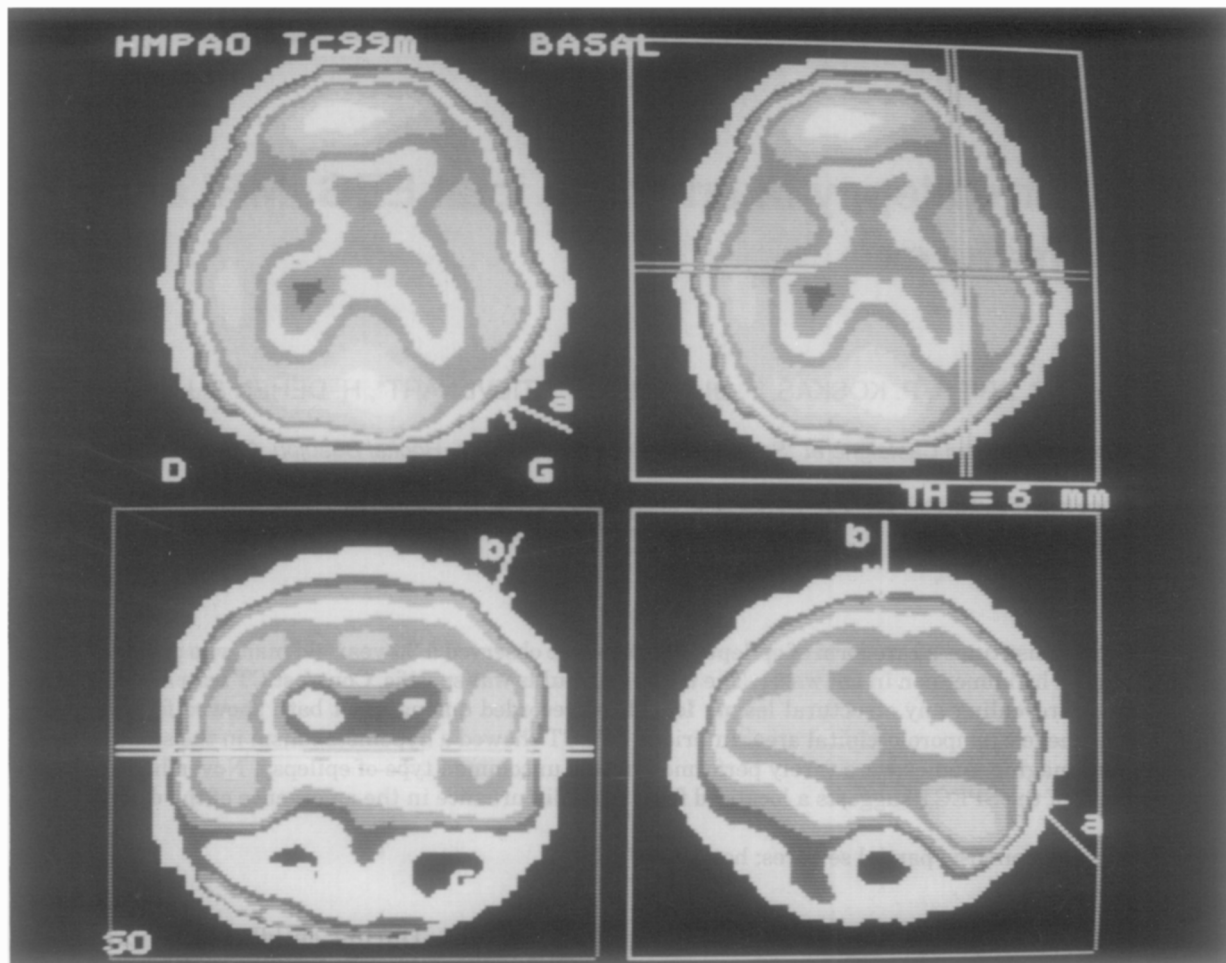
Transverse, coronal and sagittal slices of interictal SPECT (HMPAO Tc 99 m, transverse slices obtained 10 min after injection in a plane parallel to the orbito-meatal line, reconstruction with a Wiener filter). Transverse views 5 cm above the orbito-meatal line show marked hypoperfusion predominating in the left temporo-occipital region.
